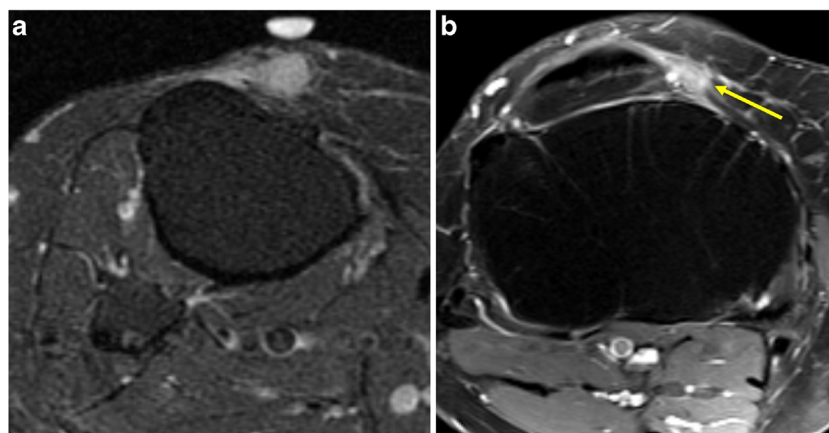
A 69-year-old woman with an indeterminate soft-tissue mass in the anterior pretibial soft tissues, highlighting how unplanned excision increases risk of local recurrence (LR). a Pre-operative axial fat-suppressed proton density-weighted (PD) image shows the small 1.5-cm mass in the pretibial subcutaneous soft tissues. The patient underwent unplanned excision at an outside facility. b Axial post-contrast fat-suppressed T1-weighted image from routine surveillance MRI 3 years later
